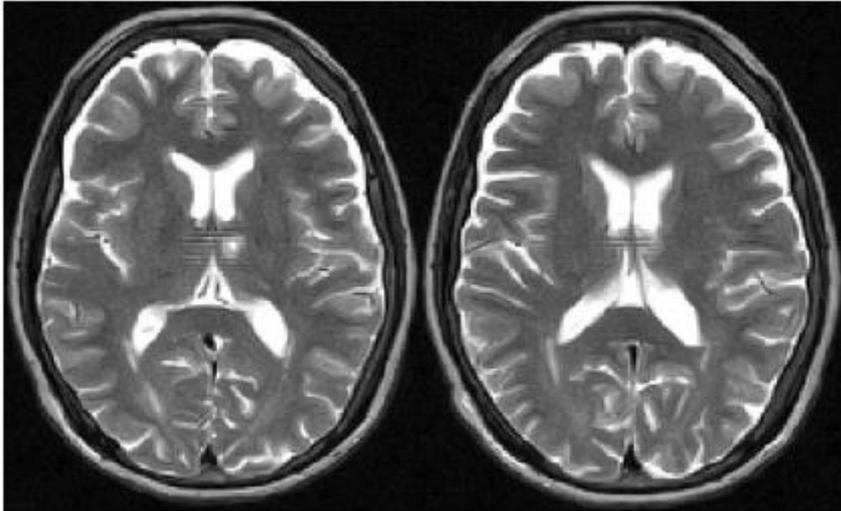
T2-weighted MRI at 46.6 months after the initial brain treatment for case 1
